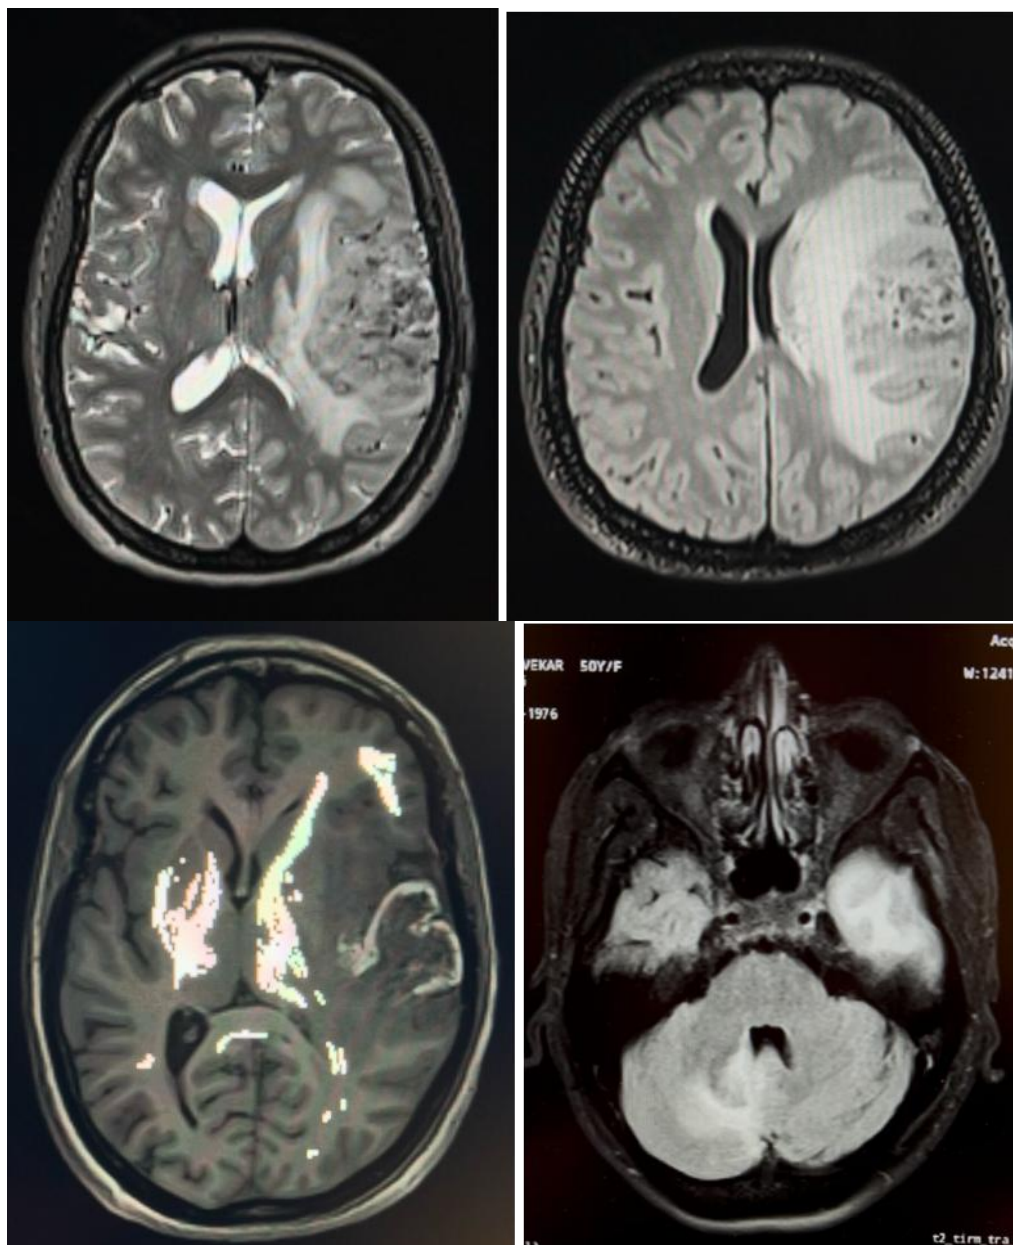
Preoperative MRI brain. Preoperative MRI brain showing an irregular, ill-defined, heterogeneously enhancing lesion involving the left fronto-temporo-parietal/perisylvian region with significant perifocal edema, mass effect, partial effacement of the left lateral ventricle and midline shift. An additional smaller lesion is seen in the right cerebellar hemisphere (last image), raising suspicion of multicentric glioma.
